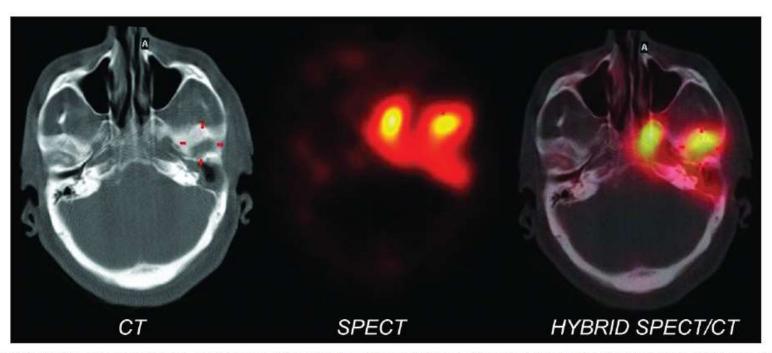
Hybrid single photon emission tomography/computed tomography of the skull (transaxial view) of the patient in Figure 1 shows increased trace the petrous part of the left temporal and sphenoid bones with corresponding destructive bony changes
